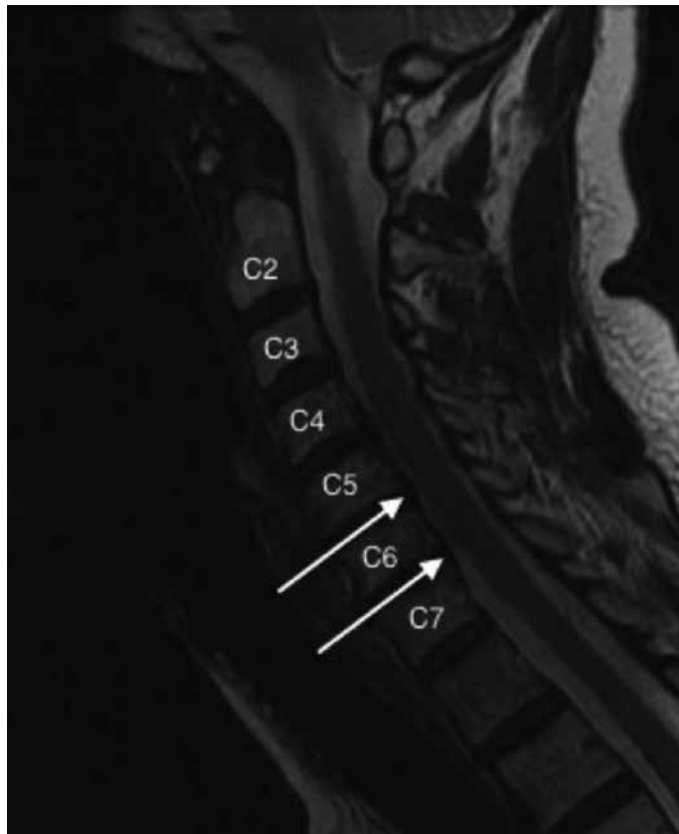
Magnetic resonance imaging of the cervical spine demonstrating near complete thecal effacement at cervical levels C5-6 and C6-7 (arrows).
